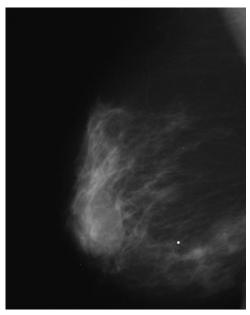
Mammography of the right breast of a patient with GLM revealed a new retroareolar mass. The mass was estimated at 3 cm in diameter and was suspicious for breast carcinoma. Spiculations were present and margins were poorly defined. The corresponding ultrasound findings are shown in Figure 3.
